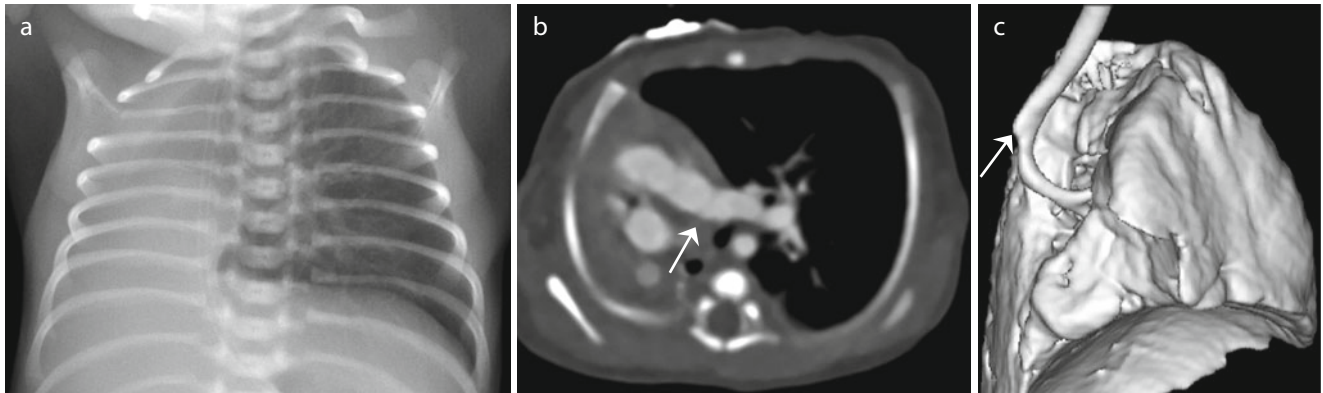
(a–c) Right pulmonary agenesis. Plain chest radiograph shows an opacified right hemithorax with a severe mediastinal shift toward the right and the hyperinflated left lung (a). Axial CT image additionally shows the absence of the right pulmonary artery (arrow)
